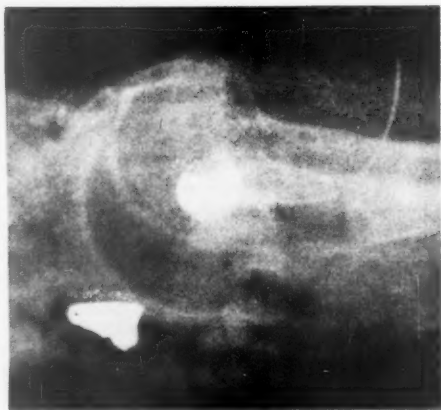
Radiograph showing the retention of Myodil in the bladder after passive drainage through the catheter with the patient supine.
